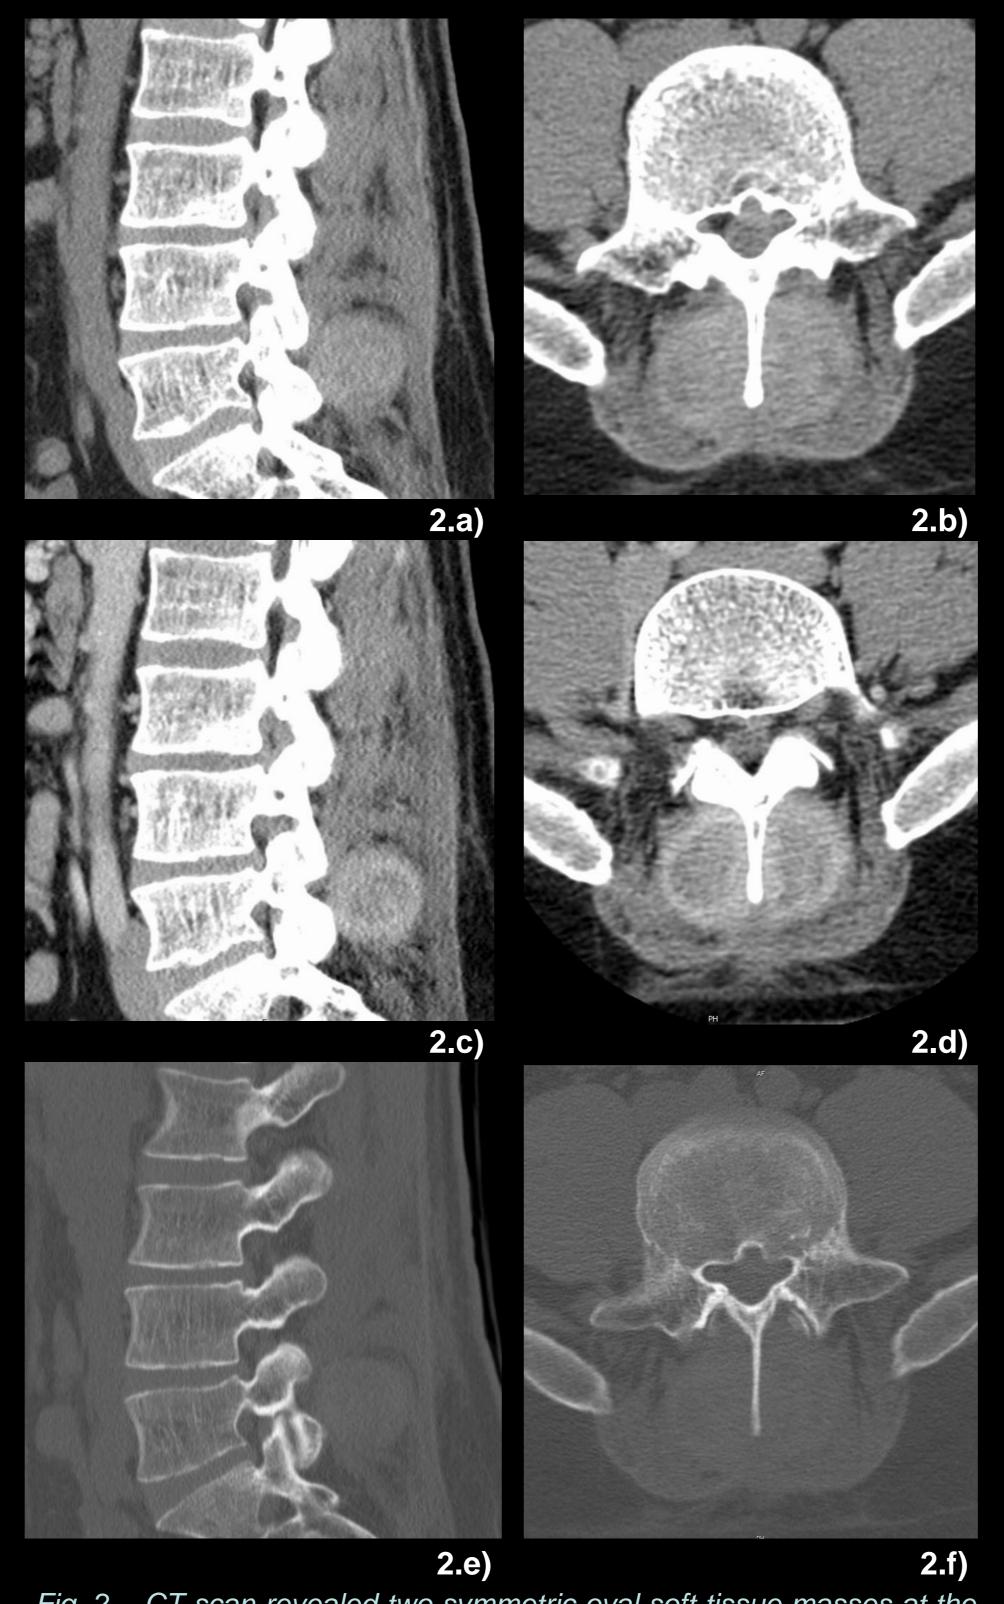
CT scan revealed two symmetric oval soft tissue masses at the Fig. 3 – Paraspinal textilomas. a) and b) Sagital and axial T1WI. c) paraspinal muscles at L5 level, with well-defined and regular contours, slightly hyperattenuated and clear peripheral capsule-like enhancement.
